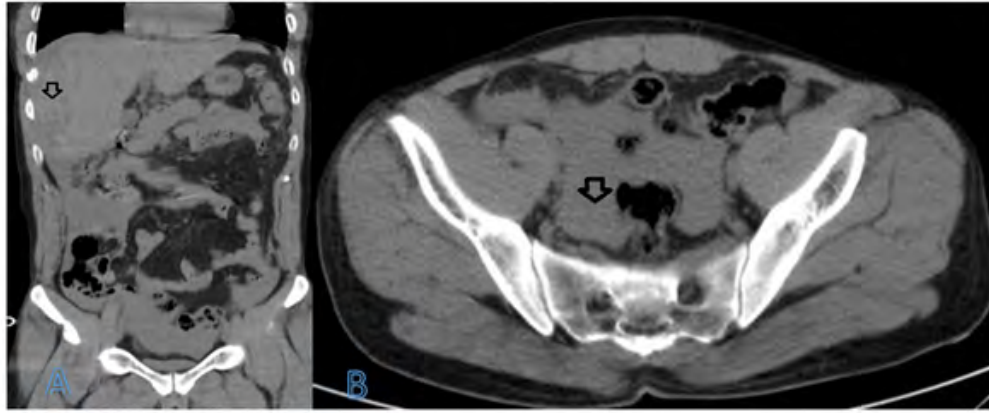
Abdominal CT scan without contrast. CT scan demonstrated heterogeneous density in right liver lob (arrow in picture A) and free fluid in abdominal space suggestive of blood (arrow in picture B).
